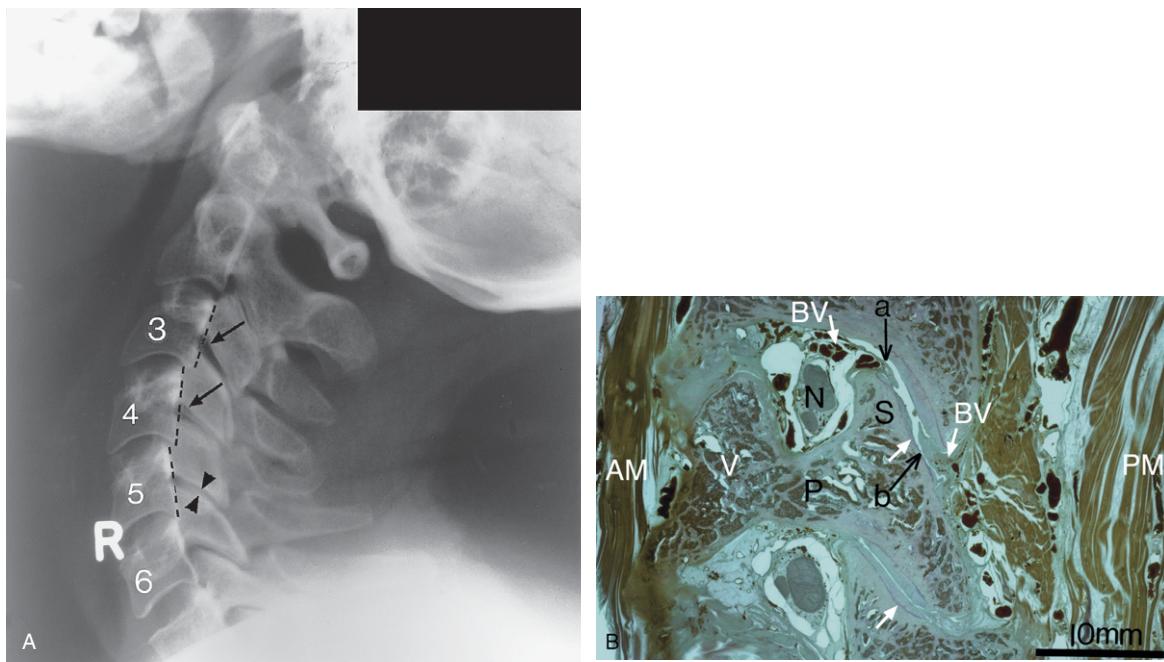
(A) Cervical spine lateral extension (functional) plain X-ray image. Note the: (i) retrolisthesis of the C3 vertebral body on the C4 body (as shown by the dotted line on the posterior aspect of the vertebral bodies) suggesting instability due to soft tissue injuries; (ii) retrolisthesis of C4 vertebral body on C5; and (iii) zygapophysial facet joint planes are parallel (for example, see arrowheads at the C5–6 facets) except at the C3–4 and C4–5 levels of instability where the zygapophysial joints 'gap' anteriorly (arrows). The soft tissues associated with the cervical spine are partly represented in (B). (B) Parasagittal section from a cervical spine showing part of the anterolateral aspect of the vertebral body (V) and the superior (S) and inferior (I) articular processes of the zygapophysial joint. Note the superior (a) and inferior (b) highly vascular synovial folds which can be nipped between joint surfaces during injury causing pain and bleeding into the joint. The lower long black arrow shows a joint with normal hyaline articular cartilage on each side of the joint's potential "space". The upper long back arrow shows a joint with osteoarthritic wear in the hyaline articular cartilage on the superior articular process (S). AM = anterior spinal muscles; PM = posterior spinal muscles, respectively; BV = blood vessels within the intervertebral foramen and in the synovial folds in the upper and lower poles of the joint; N = neural structures in the intervertebral foramen which are surrounded by fatty tissue and many blood vessels. P = pedicle that joins the vertebral body (V) to the posterior bony structures; S = superior articular process and I = inferior articular process, respectively, that form the zygapophysial joint. (Reproduced with permission from Giles L G F 1986 Lumbo-sacral and cervical zygapophyseal joint inclusions. *Manual Medicine* 2: 89–92.) See also colour plate section Fig. vii.28B.
